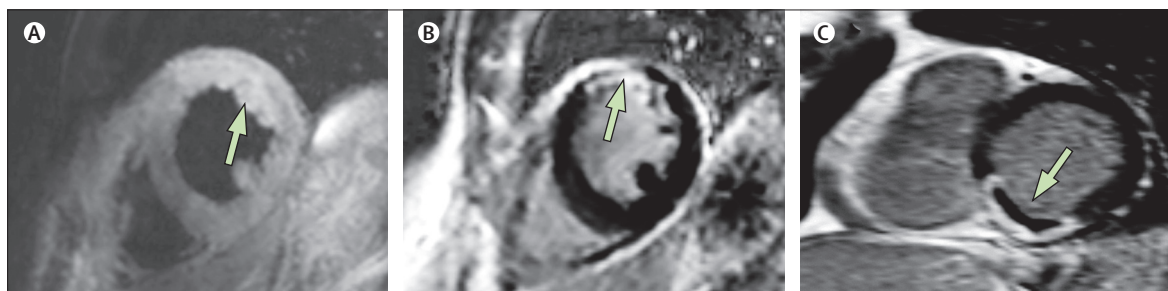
Cardiac MRI in acute myocardial infarction
